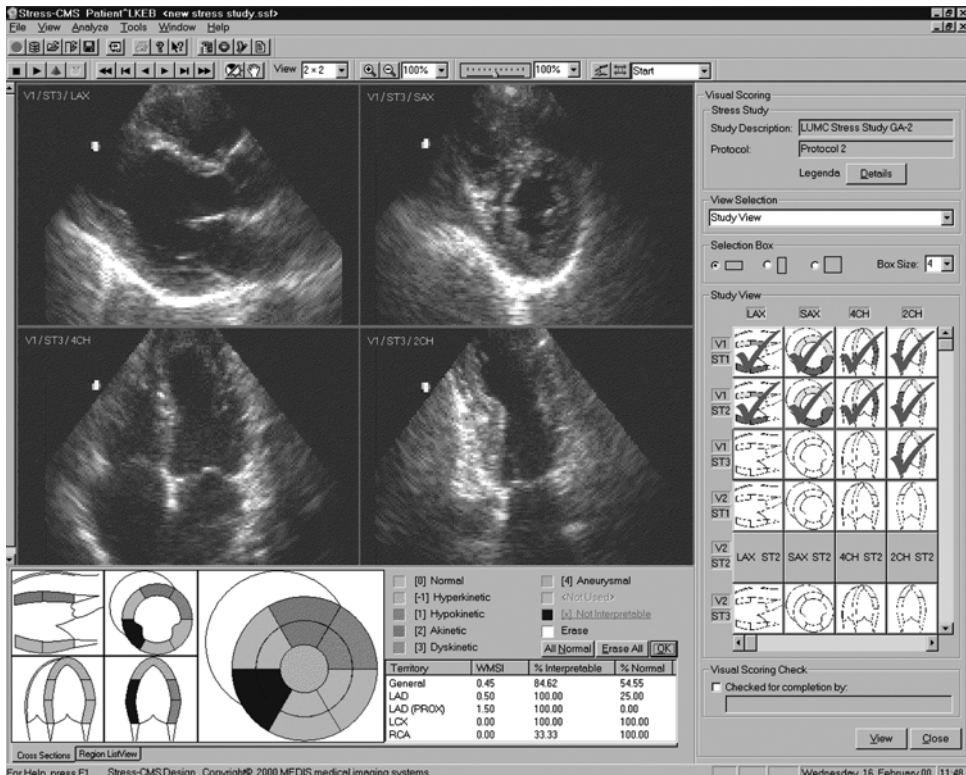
(see color suppl.) Stress echocardiography. Top: quad screen showing four standard cross sections. Bottom: bull's eye display showing 13 segments of the cardiac wall for visual scoring (from Stress-CMS prototype, Medis medical imaging systems bv)
